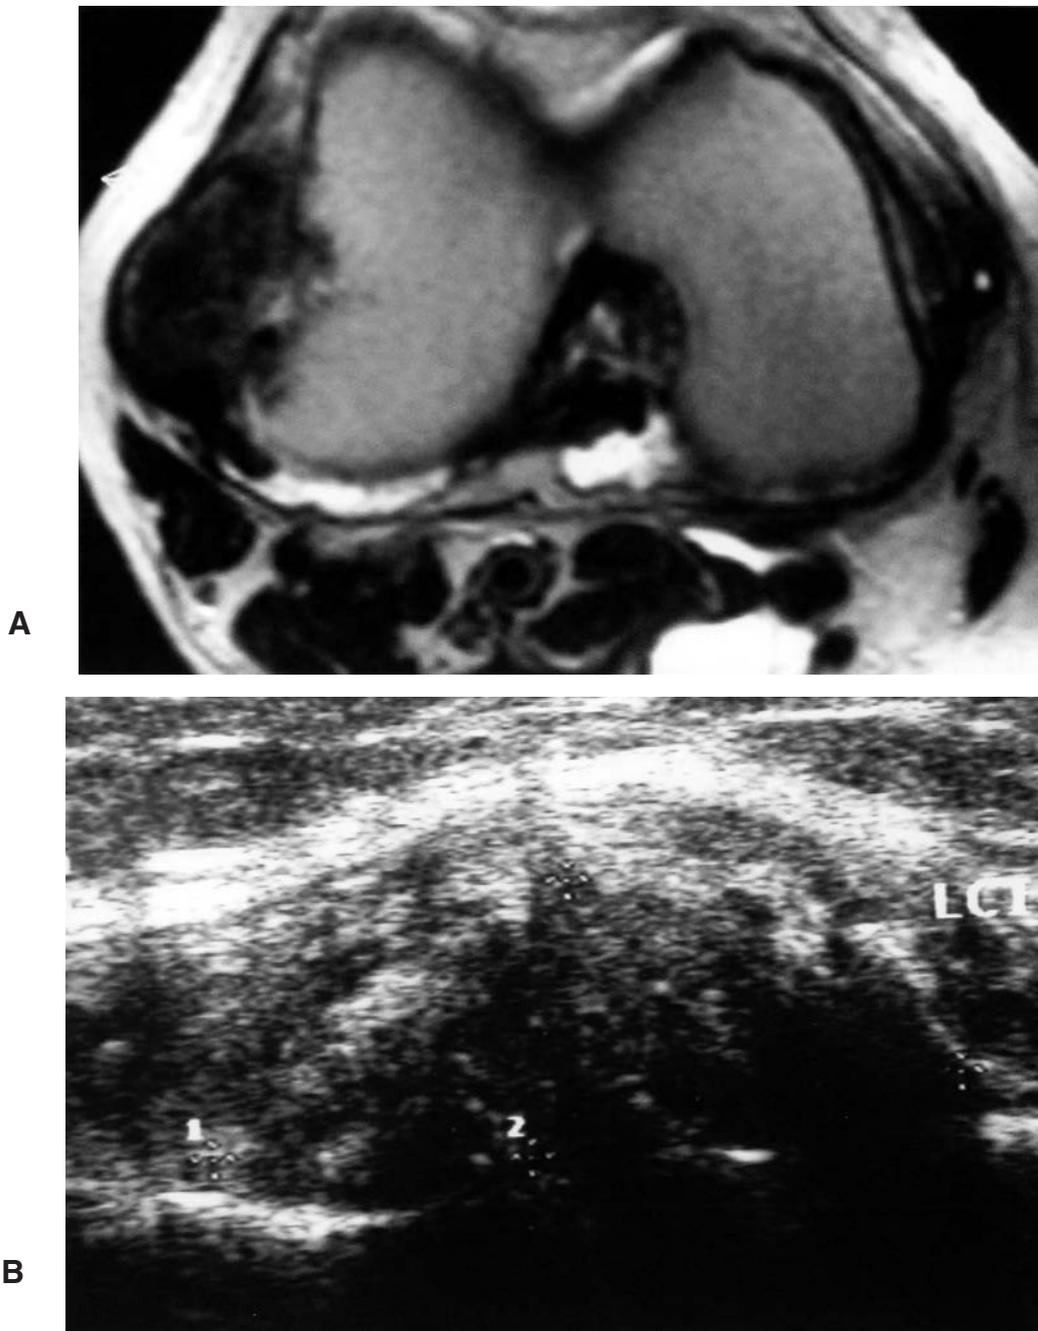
Tophi observed in the knee joint with MRI (A) and US (B), lying deep to the inner collateral ligament.
